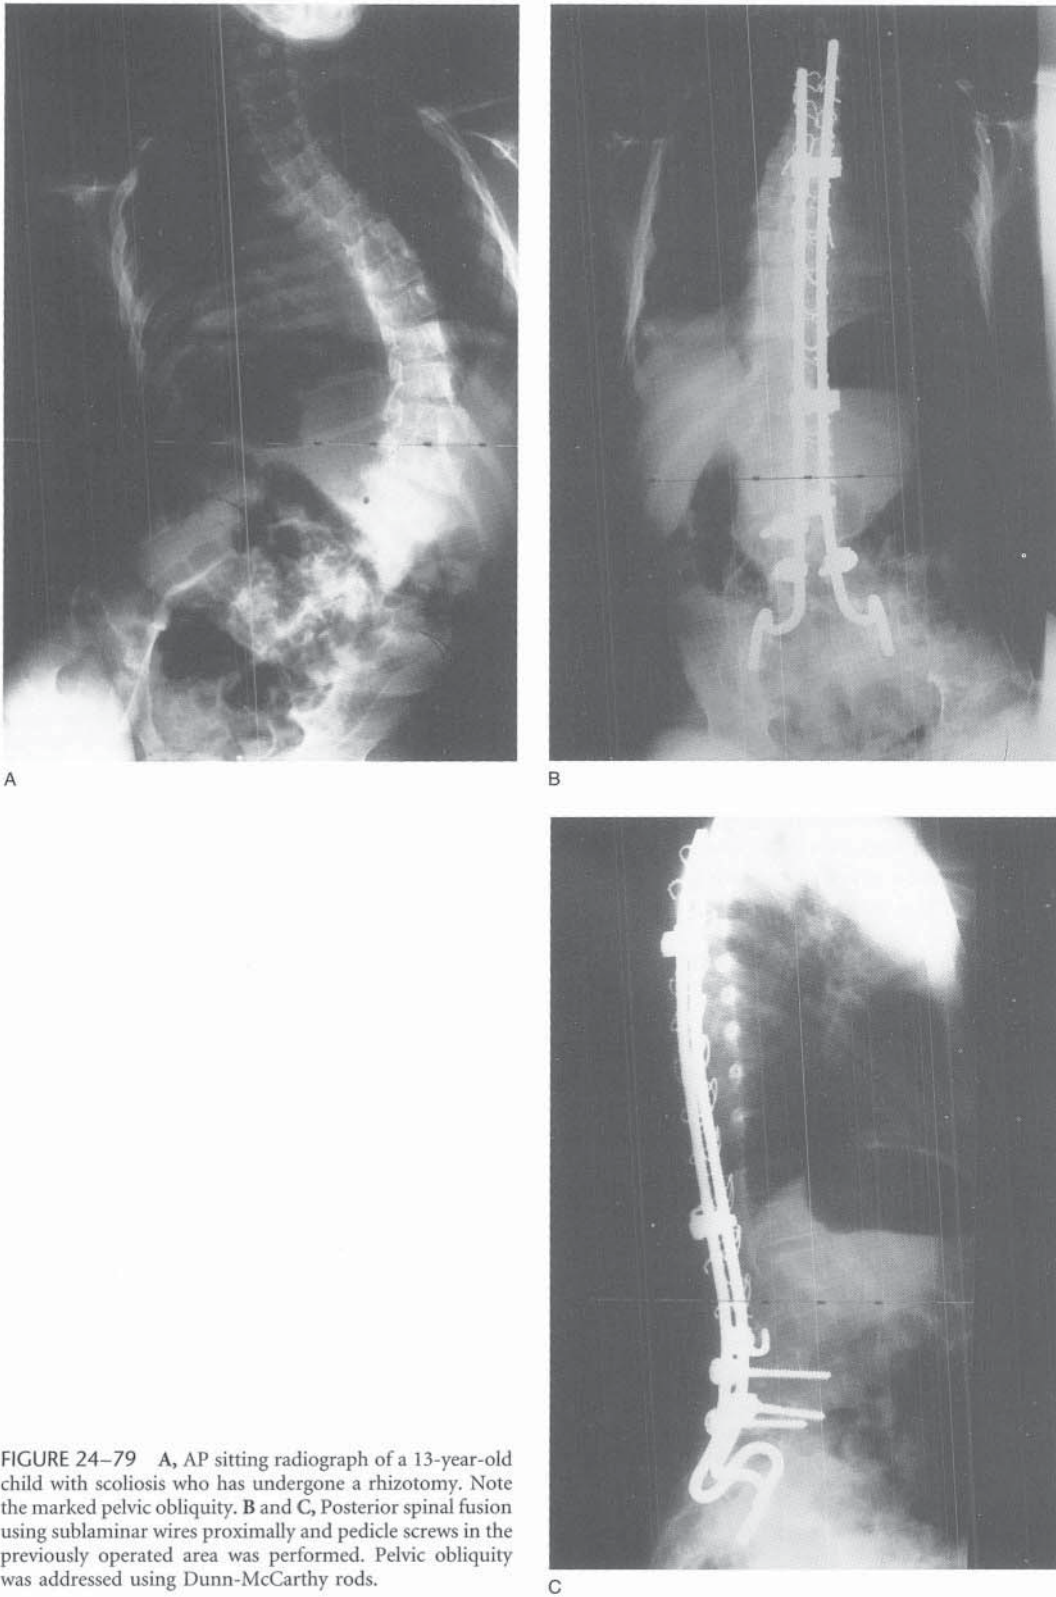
A, AP sitting radiograph of a 13-year-old child with scoliosis who has undergone a rhizotomy. Note the marked pelvic obliquity. B and C, Posterior spinal fusion using sublaminar wires proximally and pedicle screws in the previously operated area was performed. Pelvic obliquity was addressed using Dunn-McCarthy rods.
